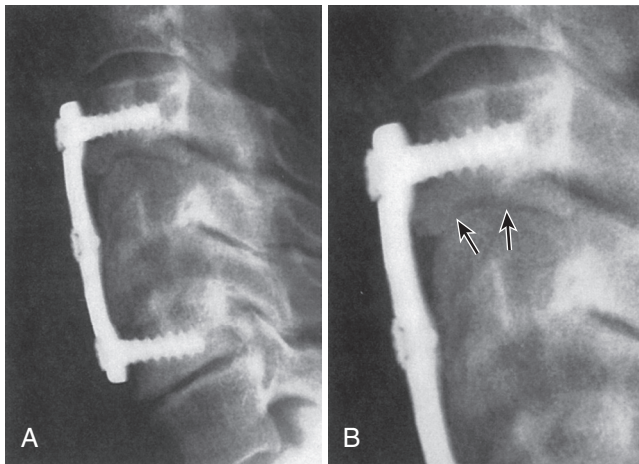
A ventral rigid cervical implant caused stress shielding. This resulted in nonunion (pseudarthrosis) in a patient with preexisting osteoporosis, as depicted. Arrows indicate the location of the nonunion (pseudarthrosis). A, Lateral radiograph; B, close-up. (From Benzel EC: Biomechanics of spine stabilization, Rolling Meadows, IL, 2001, American Association of Neurological Surgeons.)
